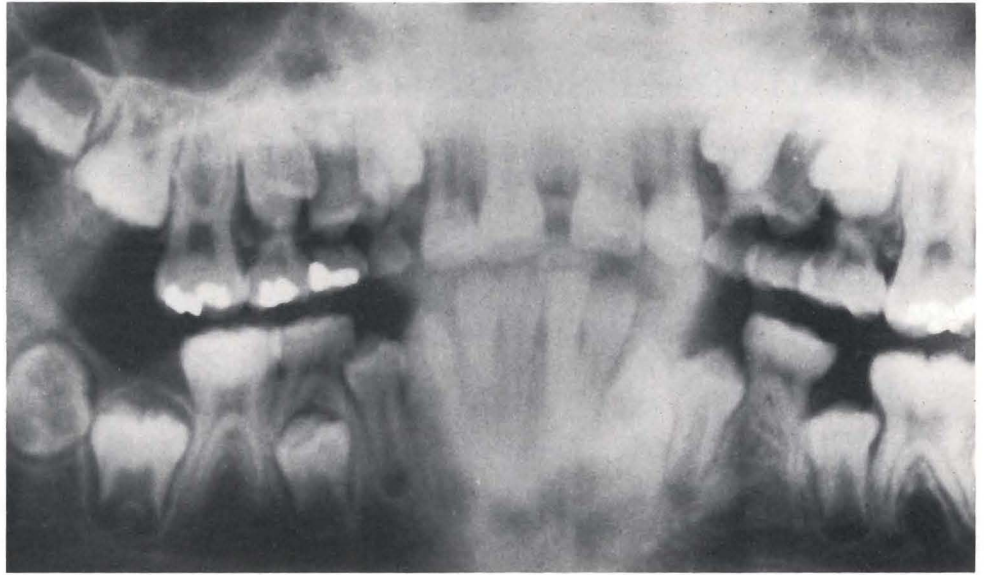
Panorex radiograph showing the transposed position of the mandibular second premolar.
